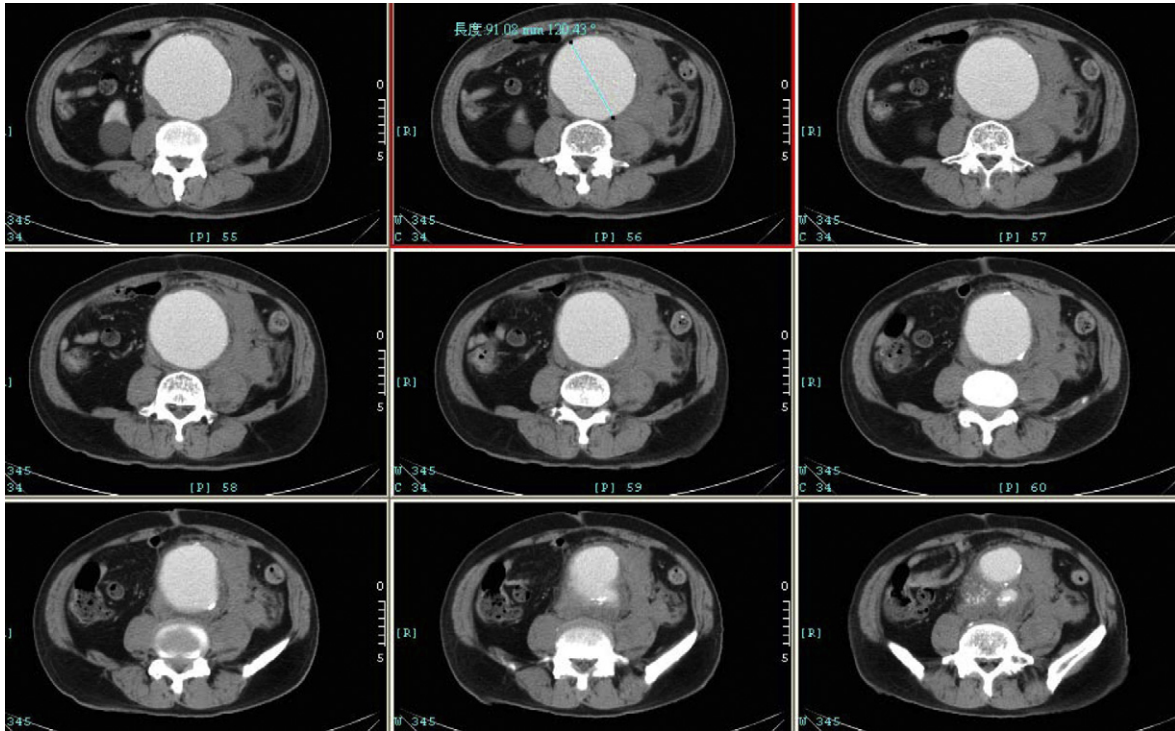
Computed tomography of typical contained rupture abdominal aortic aneurysm in patient B. There is massive retroperitoneal hematoma surrounding the aortic wall but no contrast leak into the peritoneal cavity. The largest diameter is 9.8 cm.
